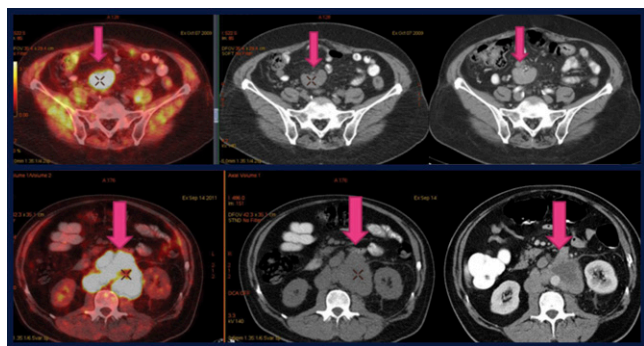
Lymph node assessment based on low-dose PET/CT. The researchers found that contrast CT as part of PET/CT contributed little or no additional information in terms of tumor size.
